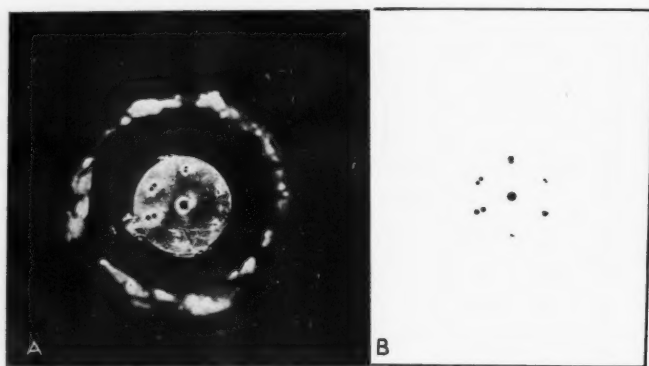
A. Photograph of stencil (perforated gold plate) for x-ray test of vision. B. Roentgenogram of stencil.
